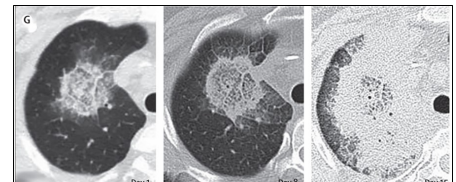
Typical rapidly progressive pulmonary mucormycosis on CT, associated with clinical deterioration (Global guideline for the diagnosis and management of mucormycosis)
